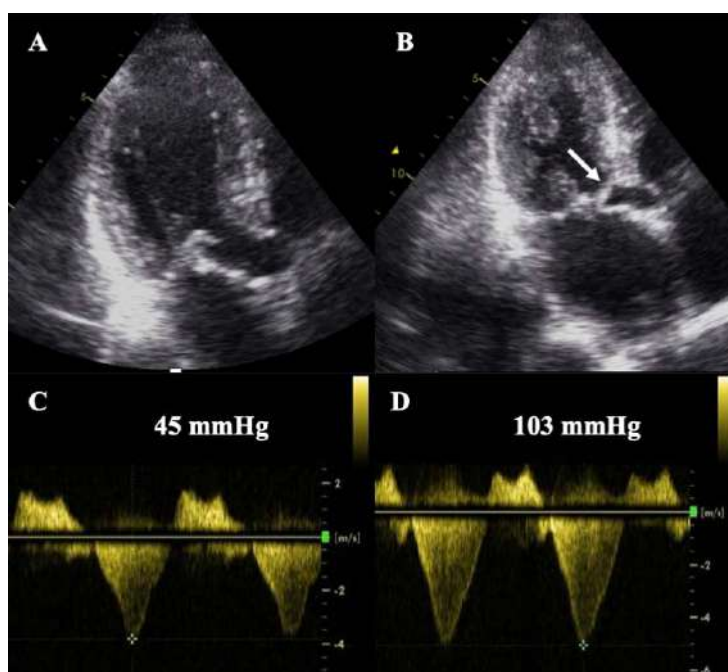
Stress echocardiography in a patient with HCM. Note the marked increase in SAM (B, white arrow) and the significant increase in LVOTO (D) at peak stress compared to the basal situation (A,C).
